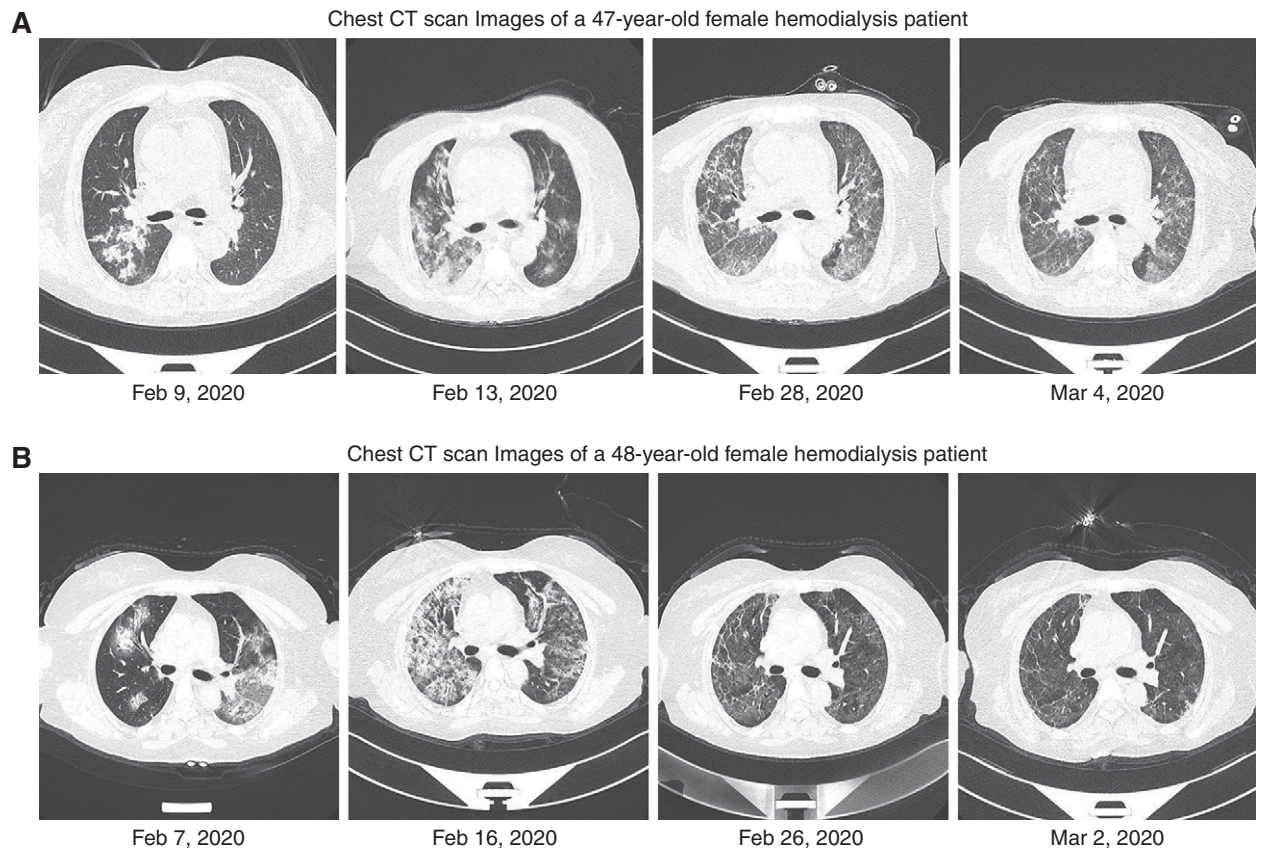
Chest computed tomographic (CT) scan images of two patients on hemodialysis infected with severe acute respiratory syndrome coronavirus 2. (A) Right-sided patchy consolidation and ground-glass opacities on admission. Expansion of pulmonary lesions, with enlargement of consolidations in right lung and appearance of ground-glass opacities in left lung after 4 days. Parts of consolidations being dissipated into ground-glass opacities in right lung, with enlargement of ground-glass opacities in left lung after 15 days. Resolution of the lesions in left and right lungs after 5 days. (B) Bilateral ground-glass opacities and consolidations on admission. Expansion of pulmonary lesions, with enlargement of bilateral ground-glass opacities and consolidations after 9 days. Bilateral consolidations being resolved in left and right lungs after 10 days. Further resolution of the lesions after 5 days. Two patients were discharged.
